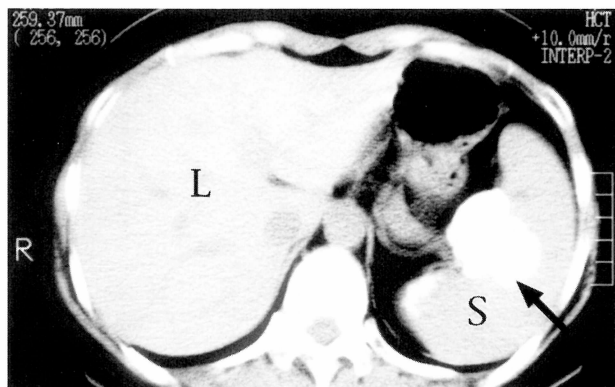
CT scan of the spleen revealing a large calcified lesion.
